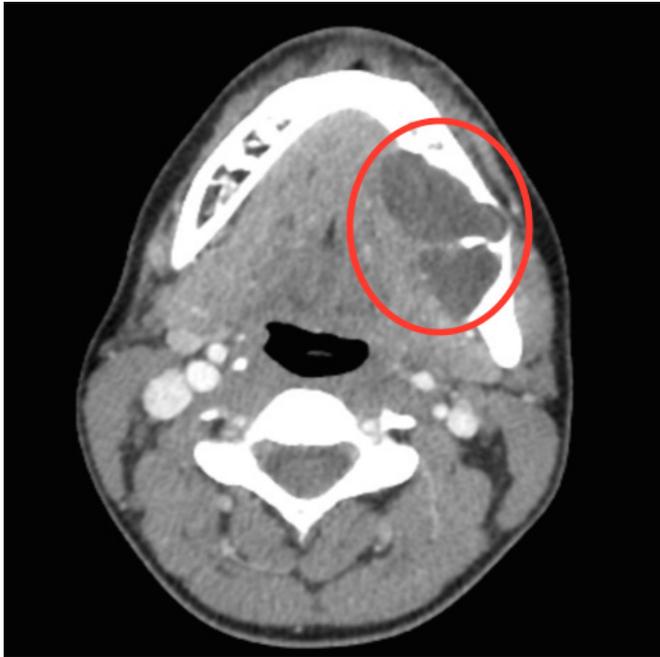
CT scan demonstrating recurrence of the ameloblastoma (in red) on the left side of the mandible. The lesion has breached both the buccal and lingual cortical plates of the mandible (September 2014).
